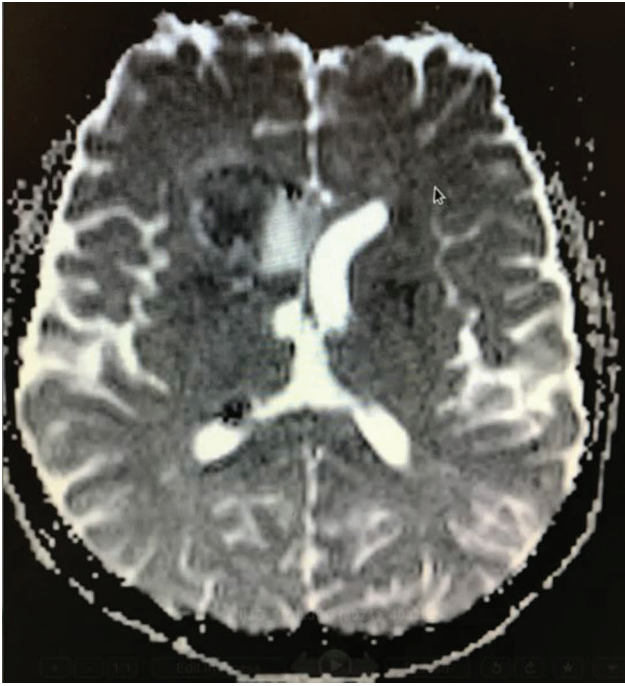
Axial MRI showing a caudate region epidermoid cyst.
